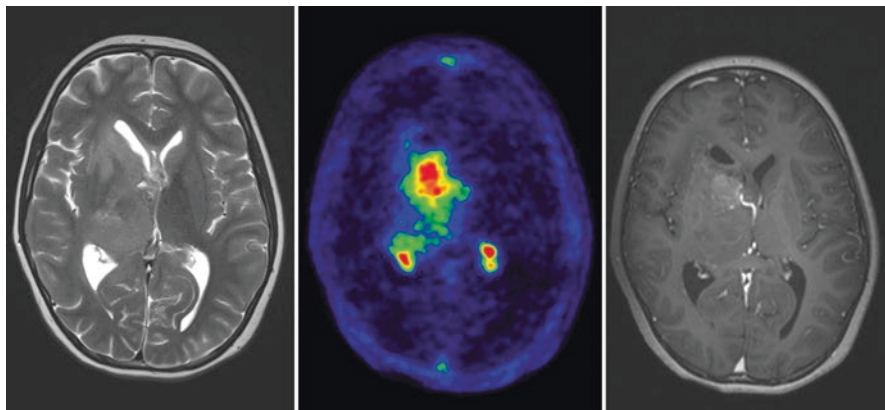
Large WHO 4 glioma with limited enhancement on MRI and intense uptake on F-Choline PET
